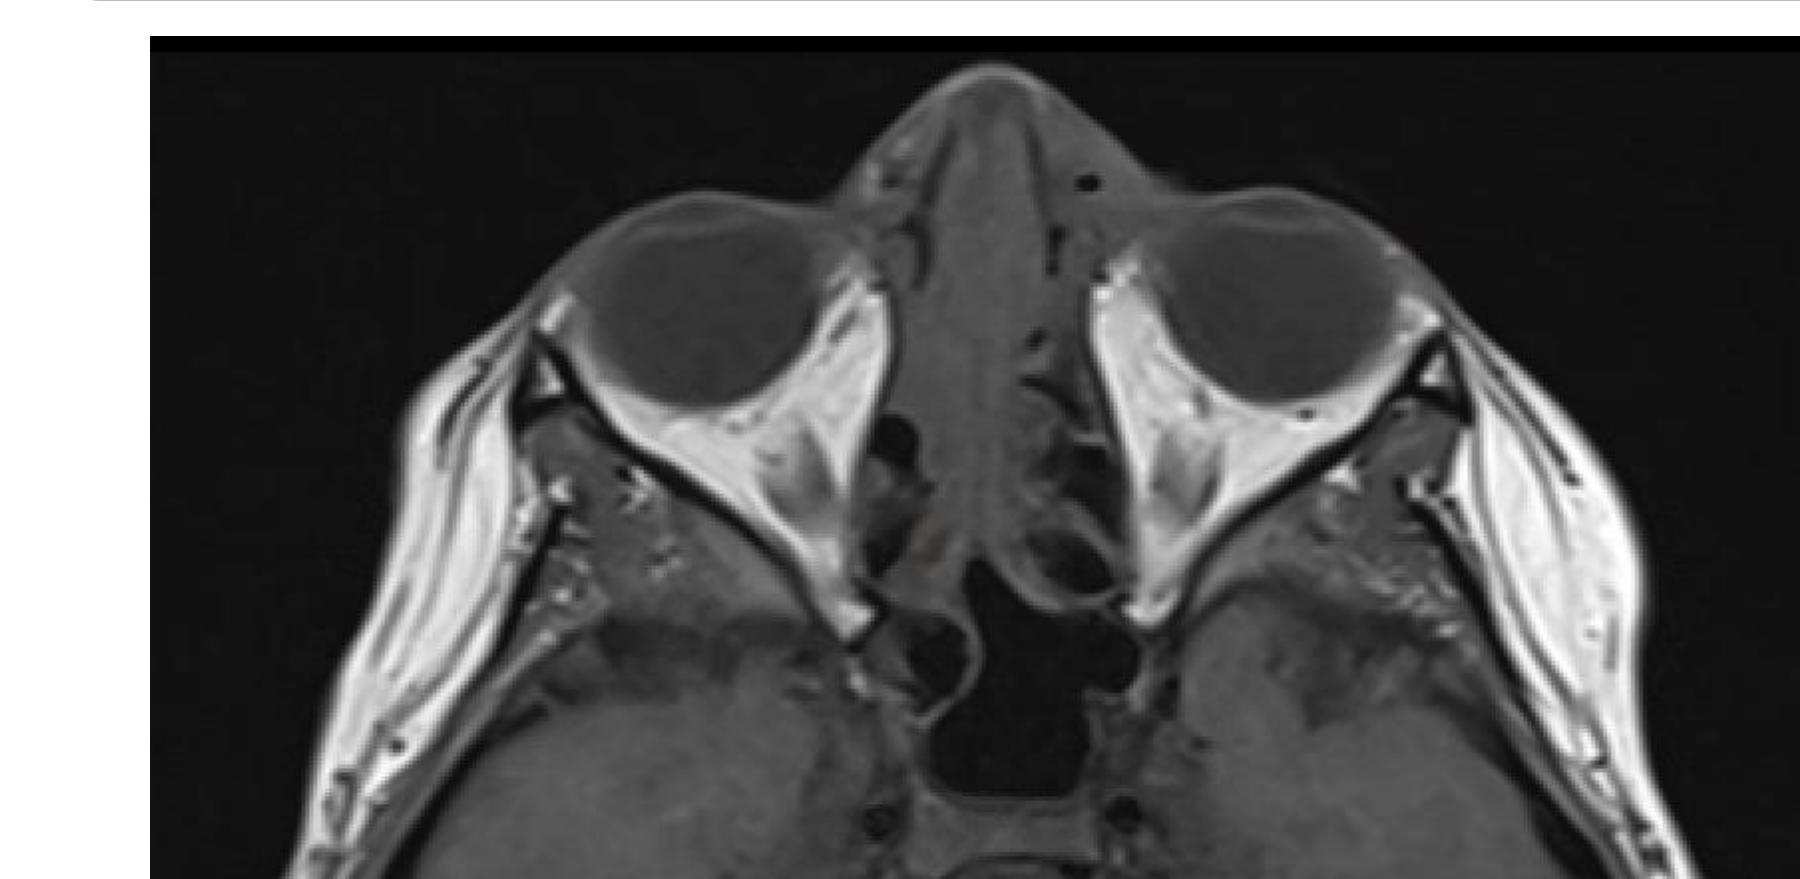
MRI Orbit 10/2024
